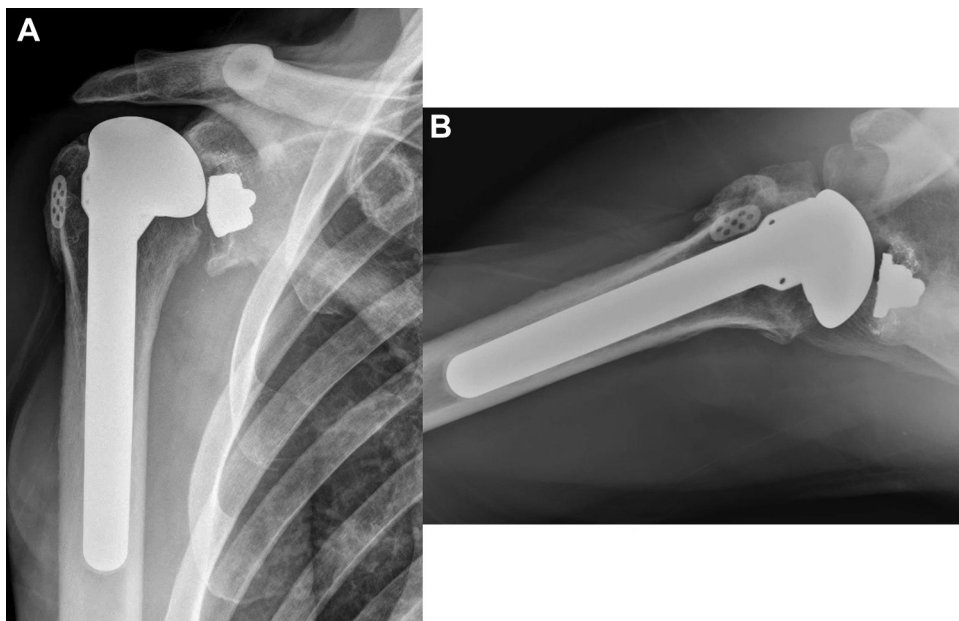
(A, B) Trabecular Metal component erosion in patient with cemented Trabecular Metal glenoid at 5.7 years' follow-up. Intra-articular metal debris, grade 2 radiolucency, evidence of rotator cuff dysfunction, and mild anterior-posterior subluxation are present. Despite having the most concerning radiographic findings, this patient demonstrated excellent clinical outcomes.
